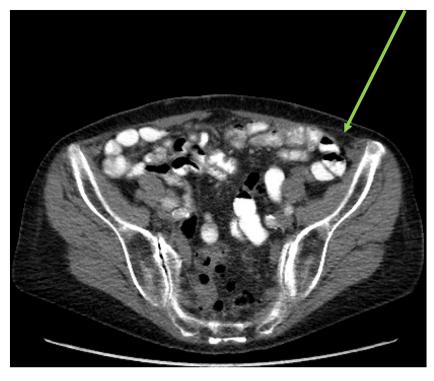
CT scan axial view showing the spigelian hernia (green arrow).
